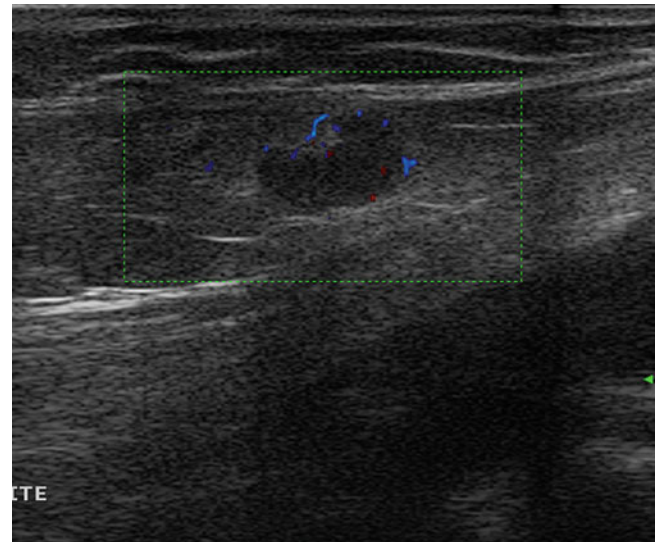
Interval lymph-node metastasis within the popliteal fossa. Directional power Doppler image. The lymph node is oval with a small and eccentric hilum and with multiple peripheral flow signals
